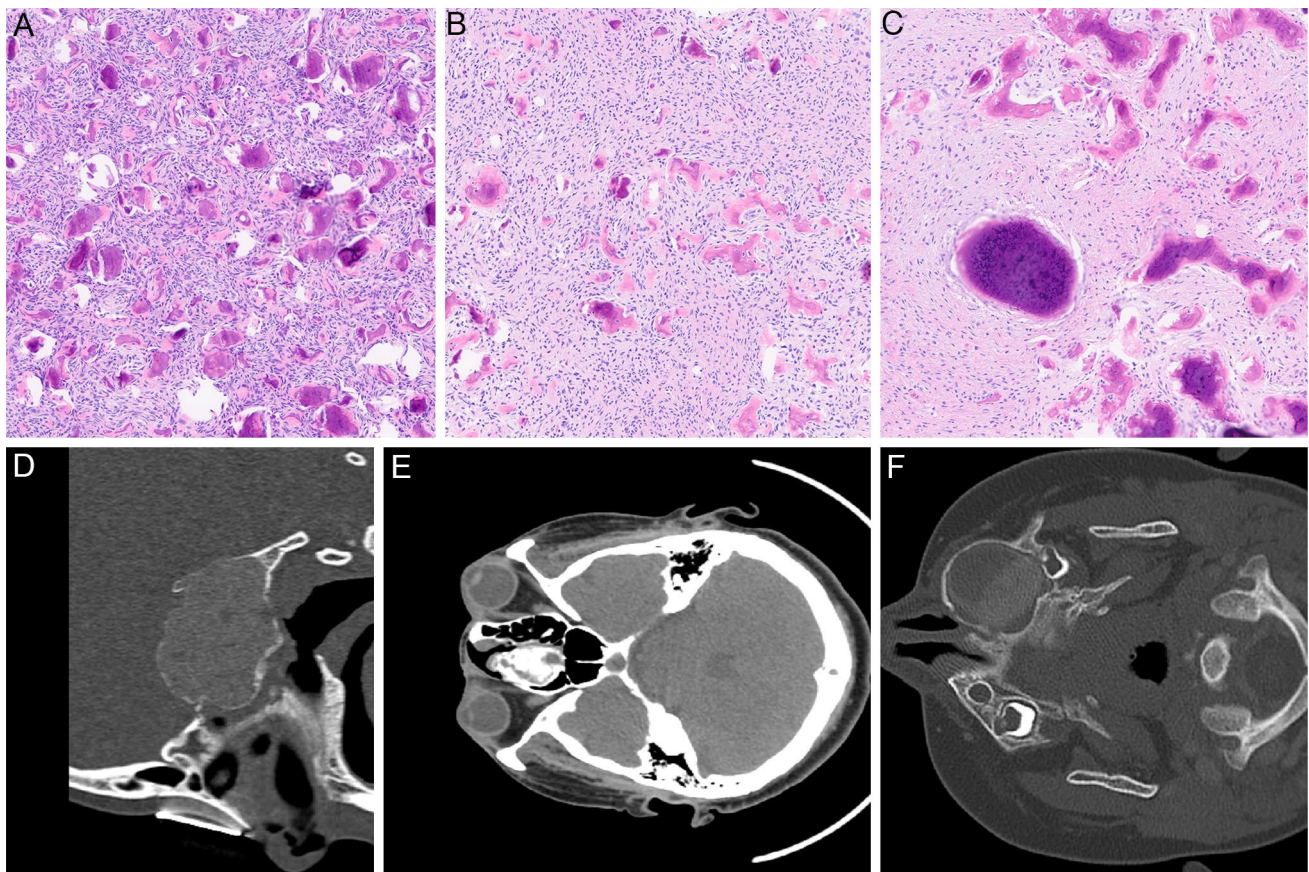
Representative morphologic and radiographic findings of ossifying fibroma. A, C Juvenile psammomatoid ossifying fibroma (case 3) with a uniform distribution of psammomatoid bony metaplasia and intervening stroma of bland spindle cells and giant cells; central skull base mass centered within the sphenoid sinuses with gross expansion of all local structures and erosion of surrounding bones without invasion. B, D Conventional/cemento-ossifying fibroma (case 6) with low-grade dense cellular fibroblastic stroma that forms new bone; well-defined soft tissue mass in the right a mass centered in the right
